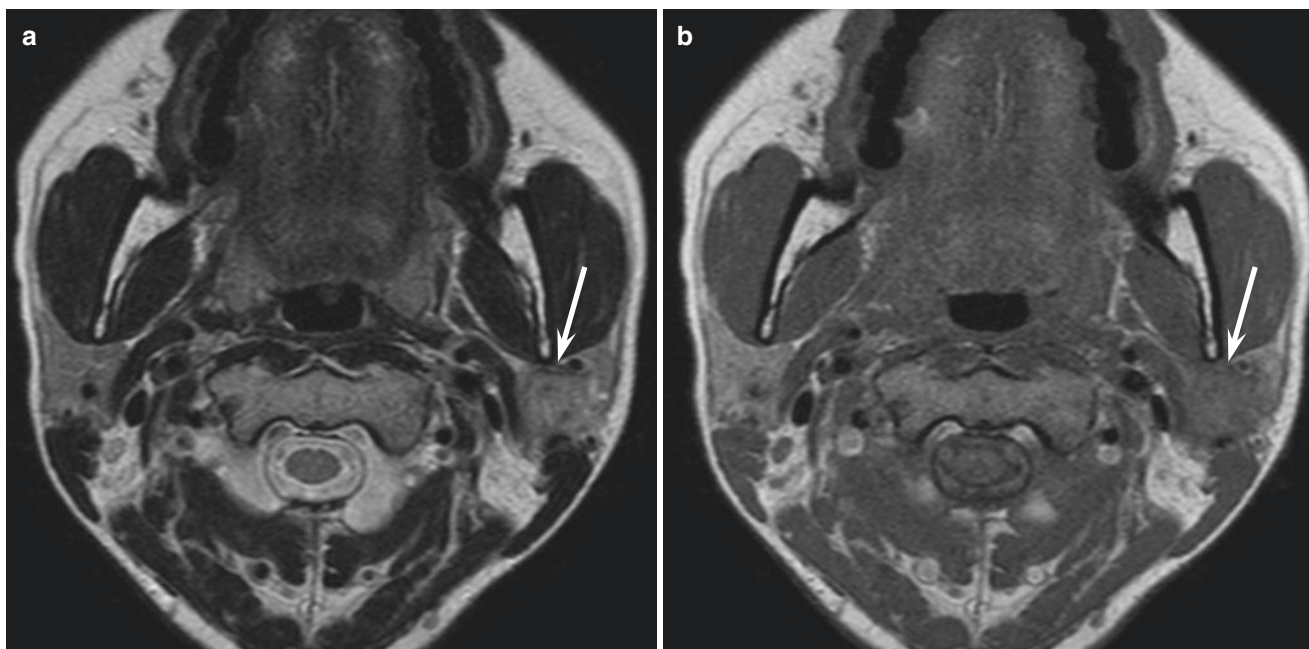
A 47-year-old woman with low-grade mucoepidermoid carcinoma of the left parotid gland. (a) T2-weighted image shows an ill-defined, heterogeneously hyper- to isointense lesion (arrow). (b) T1-weighted image shows an ill-defined, hypointense lesion (arrow)
